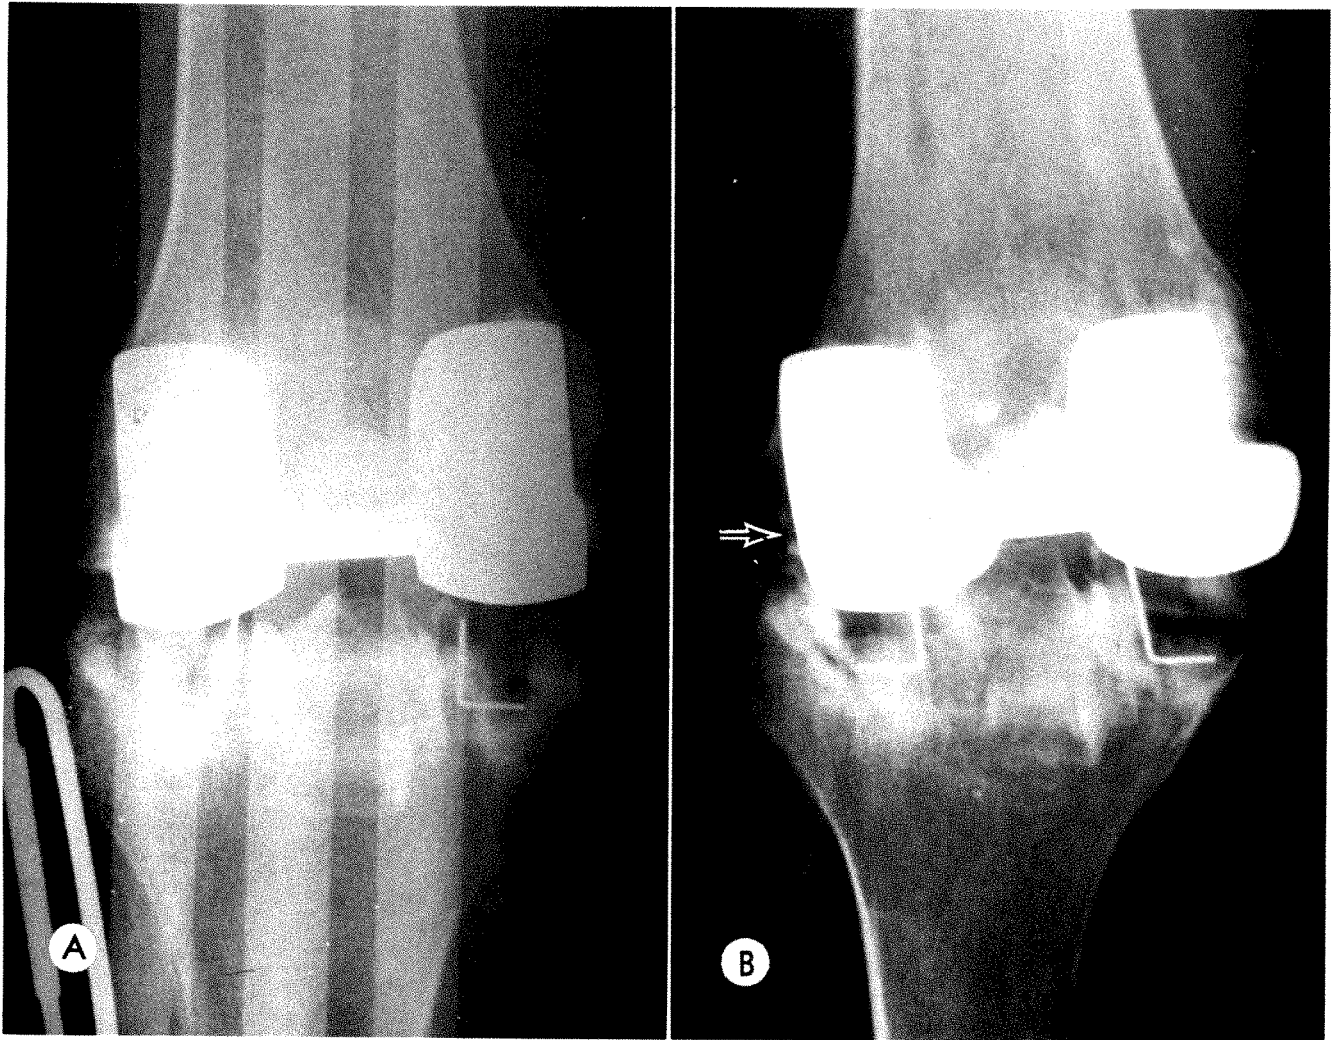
Infection. *A*, Early postoperative radiograph showing lateral femoral condyle intact. *B*, Radiograph 2 months later after infection suspected clinically demonstrating bony destruction (arrow). Pus was aspirated from joint space and at surgery femoral component was loose. Femoral and tibial components were removed and subsequent arthrodesis performed.
